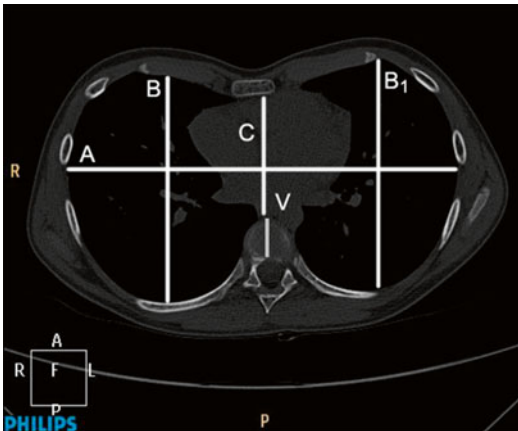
Axial CT scan showing value assessments. [A] transversal chest dimension. [B and B₁] sagittal right and left chest size dimensions. [C] sternovertebral distance. [V] vertebral body length
